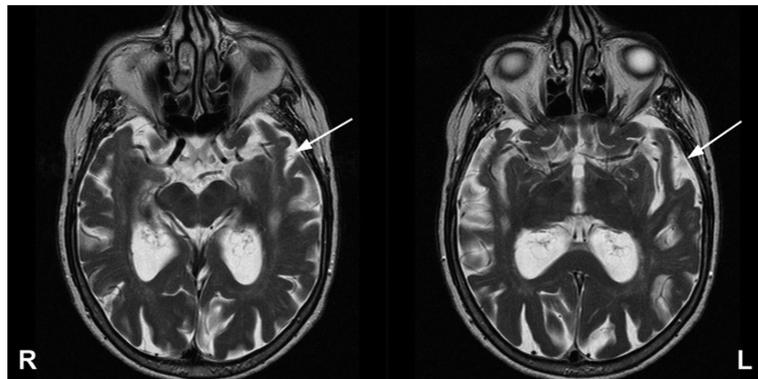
MRI-scan: Spin Echo sequences T2-weighted, parallel to the long axis of the temporal lobe, showed cortical atrophy more evident in the left side.
